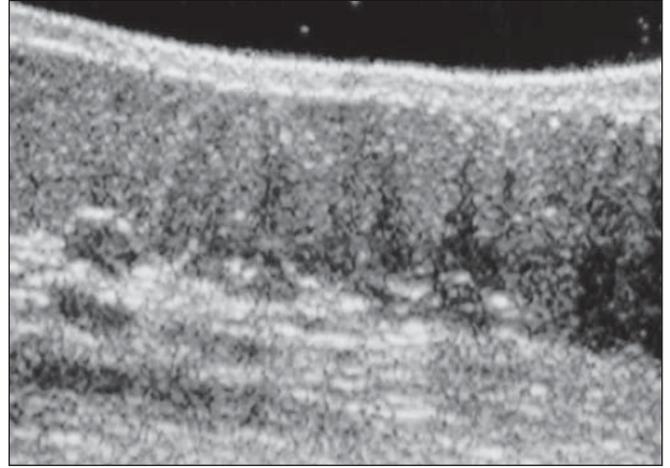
Ultrasonography of a normal skin. Sloping arrows show the limits of the dermis, and the horizontal arrows, the two layers of the dermis (superficial – hypoechogenic, and deep – hyperechogenic).
